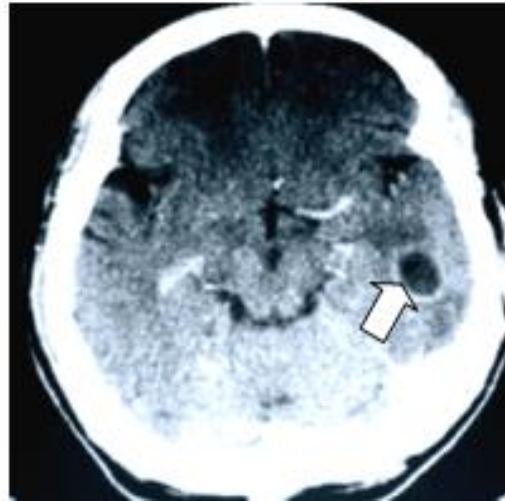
CT with contrast showing ring enhancing lesion indicating left temporal lobe abscess.
